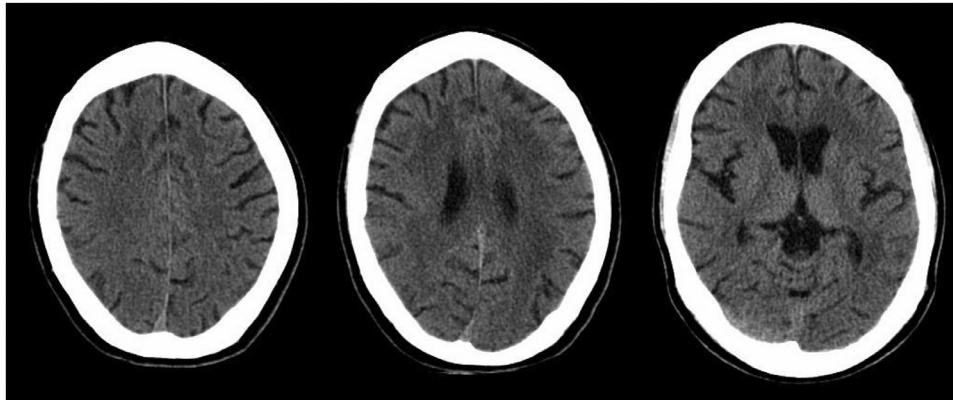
Noncontrast computed tomography (CT) of the head reveals confluent areas of hypoattenuation in the periventricular white matter and centrum semiovale. Mild generalized cerebral atrophy advanced for age is present.
